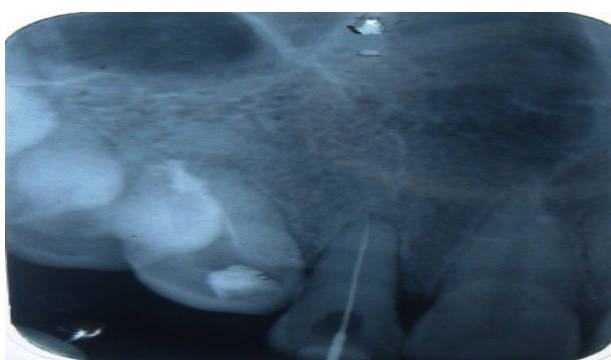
Per-operative Radiograph
